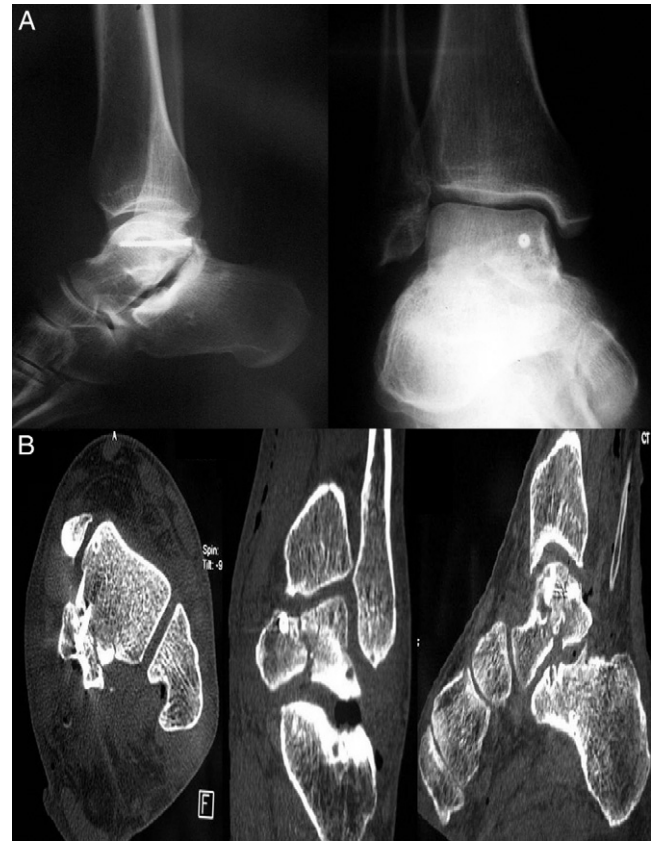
Early postoperative standard lateral and anteroposterior radiographs (A) and CT scans (B) of the reduction and fixation in Case 1.
